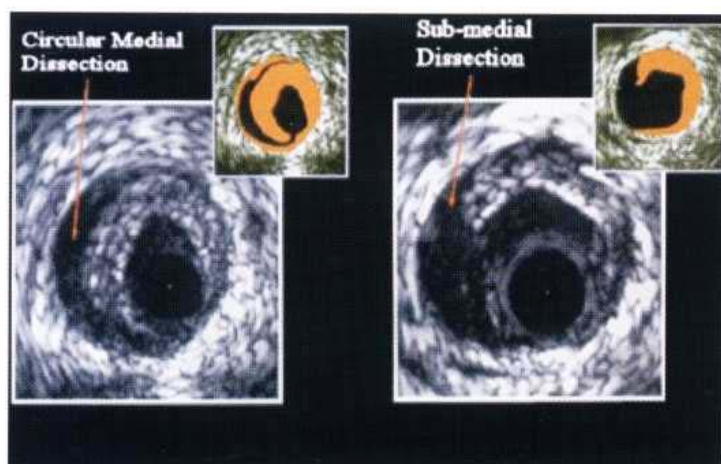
Intravascular ultrasound images of coronary artery dissections: *Left panel:* An extensive medial dissection is shown extending from 6 o'clock to 1 o'clock associated with balloon angioplasty. *Right panel:* A deep submedial dissection is shown between 7 o'clock and 11 o'clock after balloon angioplasty subsequently associated with acute coronary occlusion successfully treated by intracoronary stenting. (Courtesy of Dr N. Uren, Royal Infirmary, Edinburgh.)
